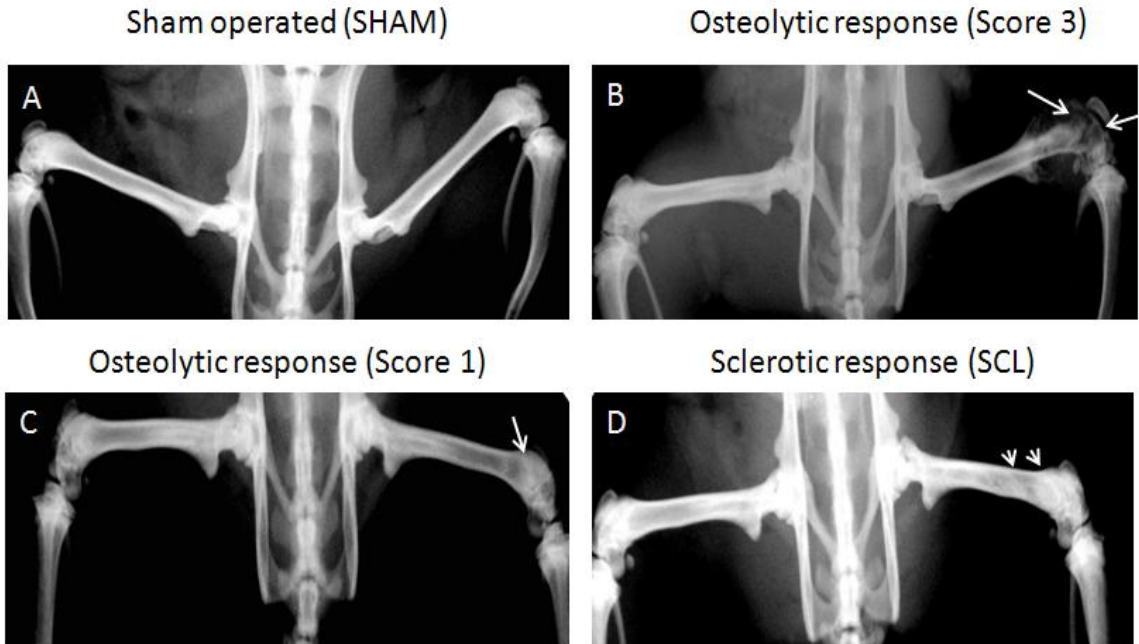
(A) Radiographical examination of different bone responses induced in this model: SHAM with no reactive bone response, (B) Osteolytic (Score 3) with soft tissue tumor burden, (C) Osteolytic (Score 1) with minimal but detectable lesion and (D) SCL with tissue hardening (white arrowheads).
